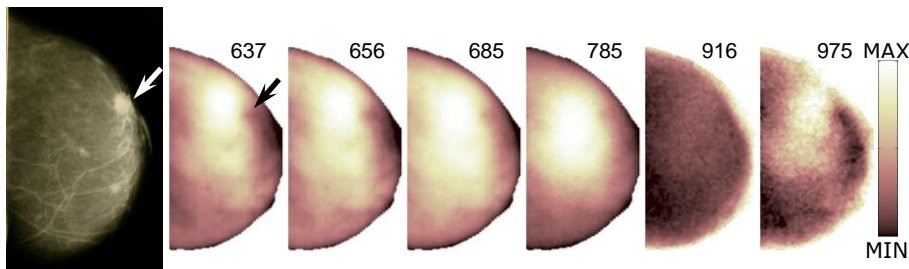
X-ray mammogram and late gated intensity images (637, 656, 685, 785, 916, and 975 nm) of the left breast (cranio-caudal view) of patient #146, bearing a lobular invasive carcinoma (max. diameter = 15 mm).
